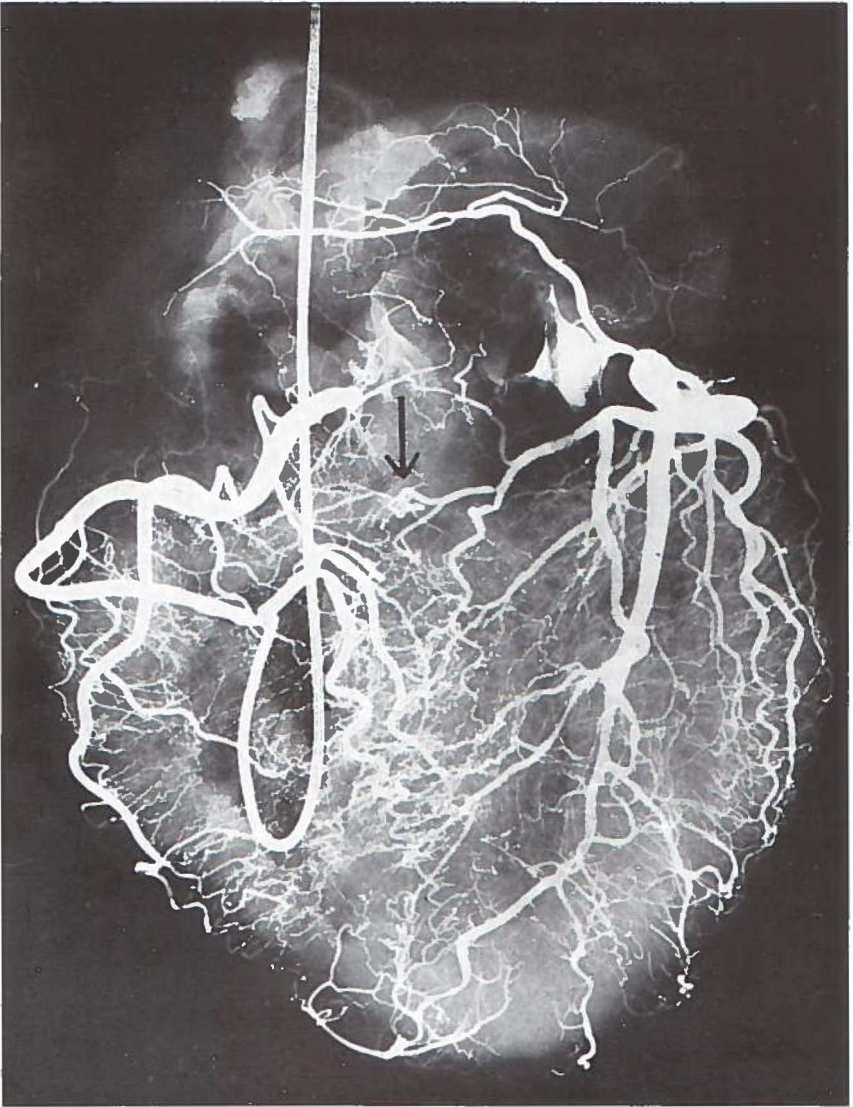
X-ray picture of coronary artery tree. The vessels supplying the A-V node are arrowed. A bipolar catheter-electrode in the right ventricle is also shown. (By courtesy of DR. E. G. SOWTON.)
